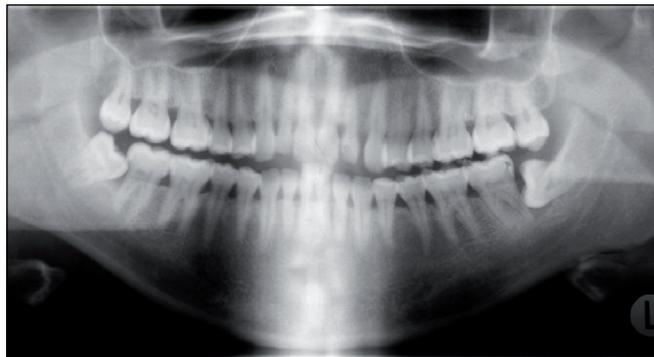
Panoramic radiography taken for the extraction of the right third mandibular molar, six months earlier, suggesting the original position of the left third mandibular molar.
